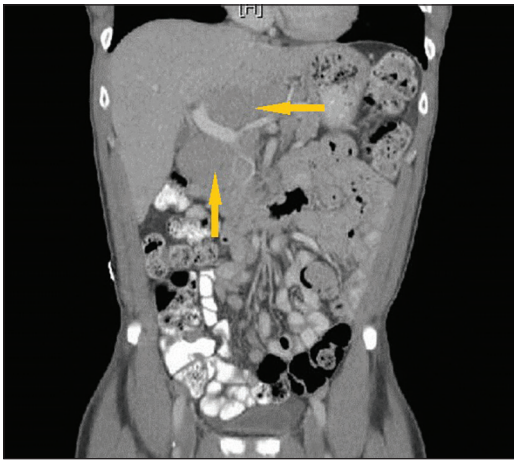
CT abdomen: Intra-abdominal lymphadenopathy (arrows)
